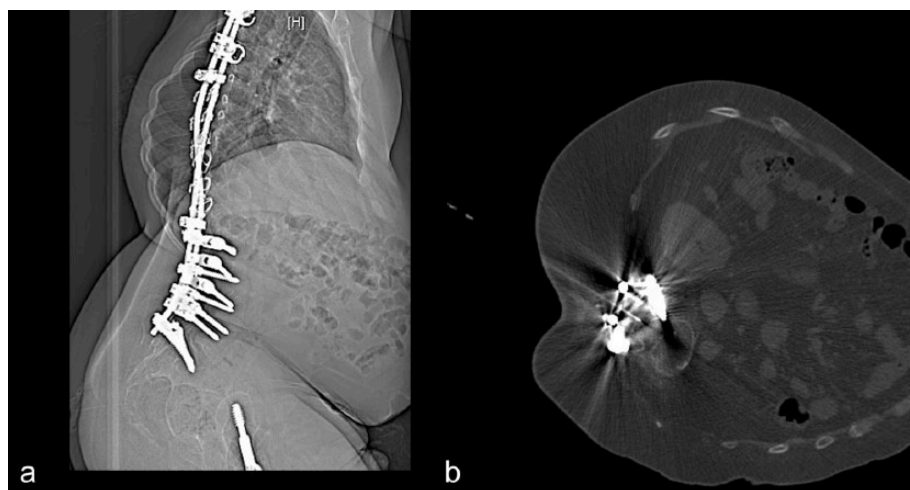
(a). Lateral tomogram of a 29-year-old patient with SMA type 2 with implanted spondylodesis and femoral head replacement. The scoliosis, the spondylodesis, and the reduced visibility of the demineralised vertebral bodies complicate the lumbar puncture without computed tomographic guidance. SMA, spinal muscular atrophy.
